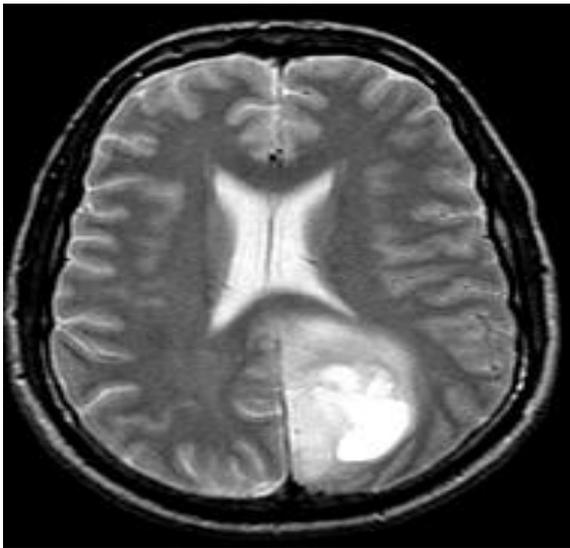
The MRI shows a region in the left occipital area with mixed signal intensity on both proton density and T2-weighted images. Enhancement with contrast reveals cystic elements within the lesion.
